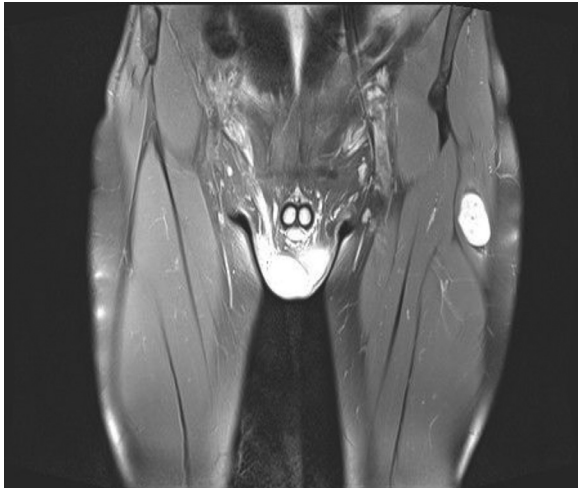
Magnetic resonance imaging (proton density-weighted fat suppression fast spin echo sequence, coronal view) revealed a spindle-shaped mass with well-defined edges situated within the tensor fasciae latae muscle.
